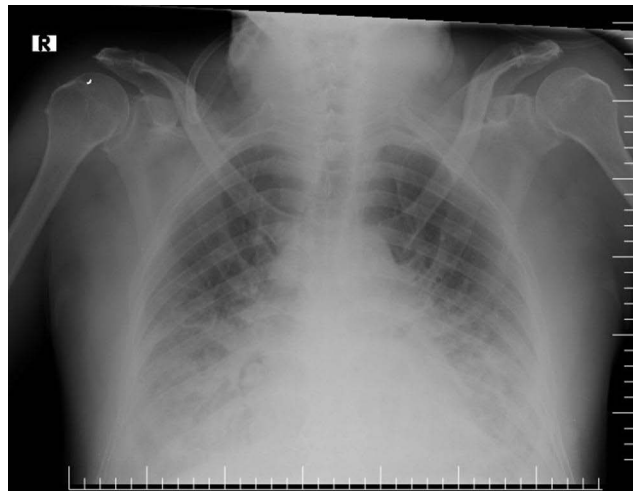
A chest X-ray showed bilateral pulmonary edema.
